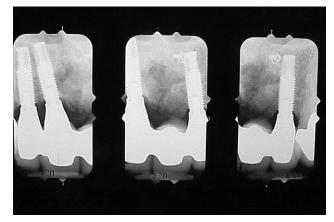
Nine-year postoperative radiograph demonstrates a steady state of bone. Note the change in the bone height from the initial 5–6 mm to the postoperative 15 mm. An excellent esthetic result had been achieved.
